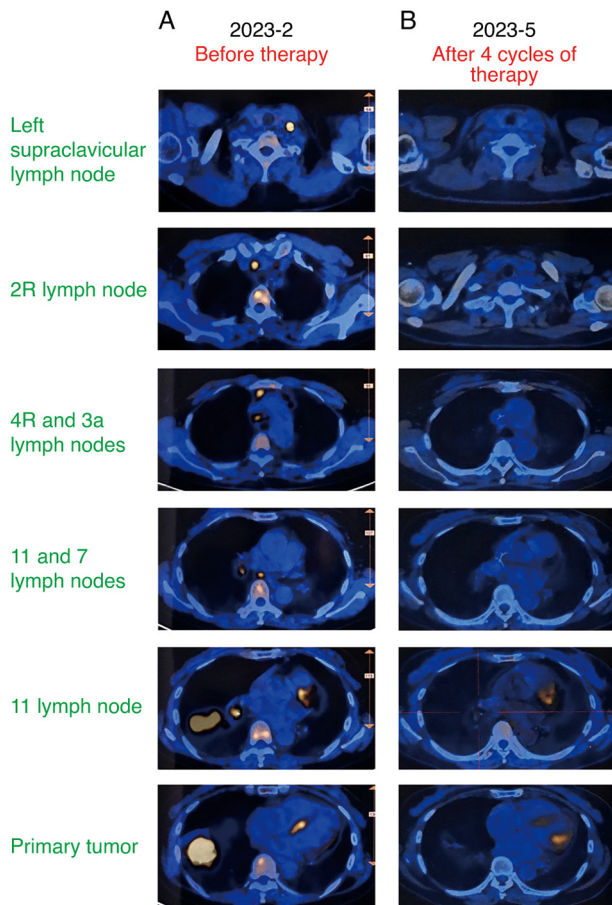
PET/CT examinations before and after induction therapy. (A) Before therapy, PET/CT showed that the tumor SUVmax was 19.0 and the left hyperplastic, 2R, 4R, 3a, 7 and interlobar regions had increased glucose metabolism. (B) After four cycles of treatment, the tumor SUVmax was 3.2 and all lymph nodes had a normal glucose metabolism. CT, computed tomography; PET, positron emission tomography.
